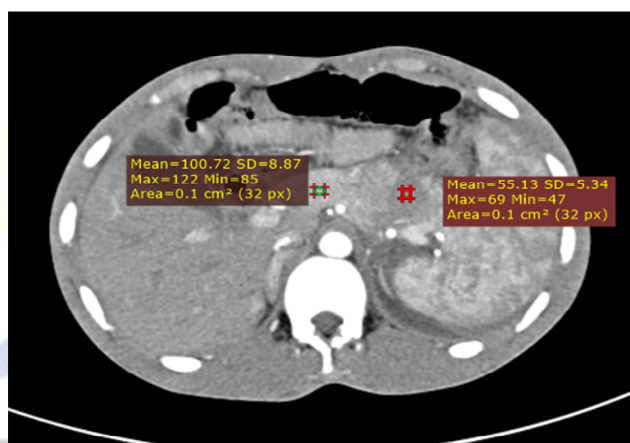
CT Axial scan showing intra-parenchymal hematoma of pancreas.
